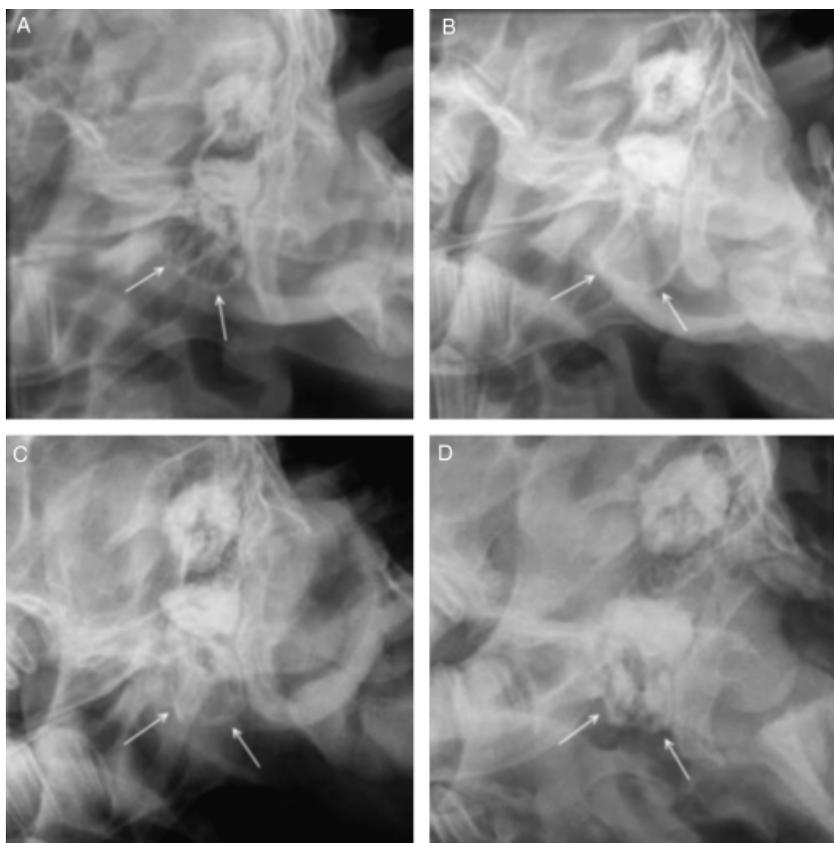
Radiographic images (20° ventral-laterodorsal oblique) of 4 different calves. (A) Normal calf demonstrating the presence of bony trabeculations within the normally air-filled bulla. (B) Affected calf demonstrating lysis of the bony trabeculations and apparent increased bulla size. (C) Affected calf demonstrating lysis of the bony trabeculations and increased soft tissue opacity. (D) Normal calf incorrectly identified as affected (false positive) based upon radiographic interpretation of increased soft tissue opacity, lysis of the bony trabeculations, and bulla wall thickening.
